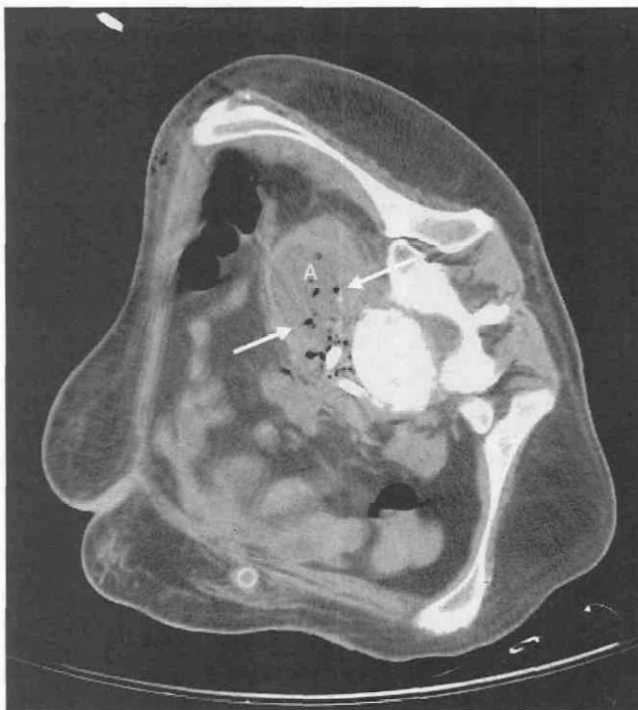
CT scan shows a fluid collection (A) containing gas bubbles (arrows), adjacent to the area of the aortic bifurcation.
